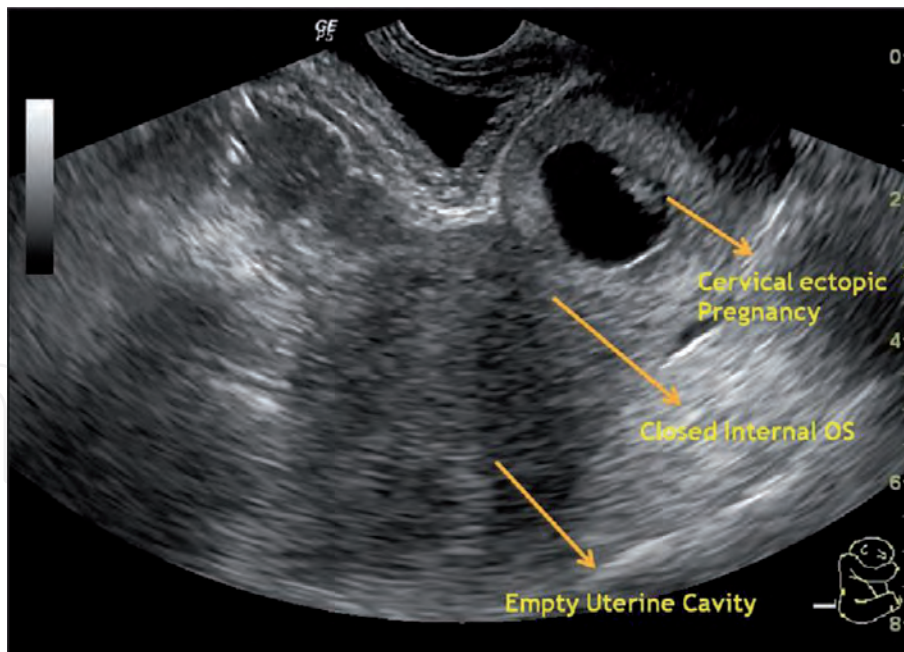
Early cervical ectopic pregnancy with embryonic pole. Transvaginal ultrasound shows: (1) an empty and normal uterine cavity and (2) a cervical ectopic pregnancy with gestational sac and an embryonic pole (arrows) [23].
